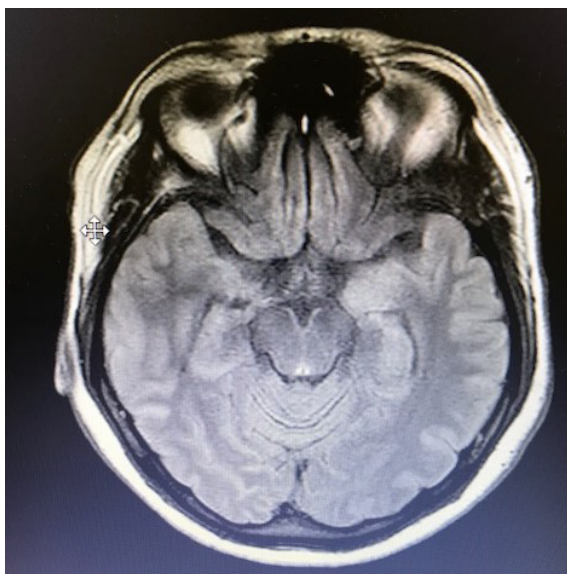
Magnetic resonance imaging demonstrating bilateral hippocampal high intensity signal on T2/Flair weighted images
